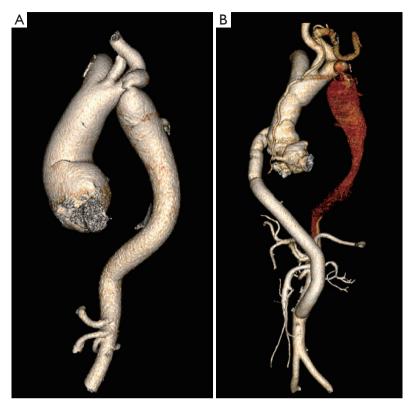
Pre- and post-operative imaging of patient No. 14. (A) Preoperative CTA showing ascending aorta dissection and PA; (B) post-repair CTA showing normal blood flow in the medial side of the descending aorta and thrombosis formed in the lateral side. CTA, computed tomography angiography; PA, poststenotic aneurysm.
